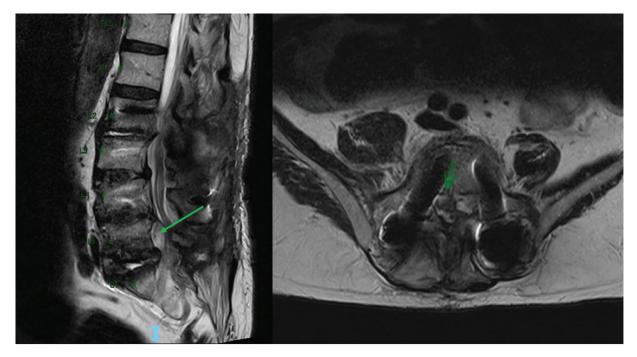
Left sagittal and right axial T2-weighted magnetic resonance images showing an abscess posterior to the L5 vertebral body.
